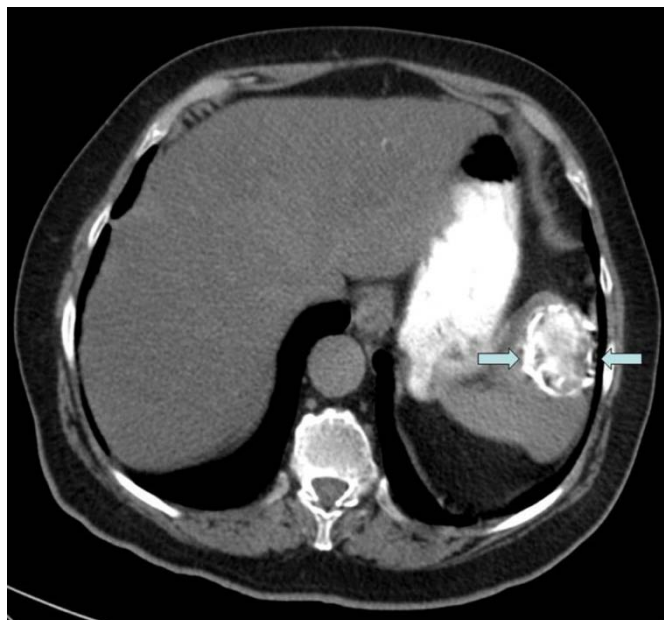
Abdominal CT scan. Mass in the upper pole of the spleen, of rounded morphology and 49 mm in length, solid-cystic, calcified coarsely edges and well defined (arrows).
